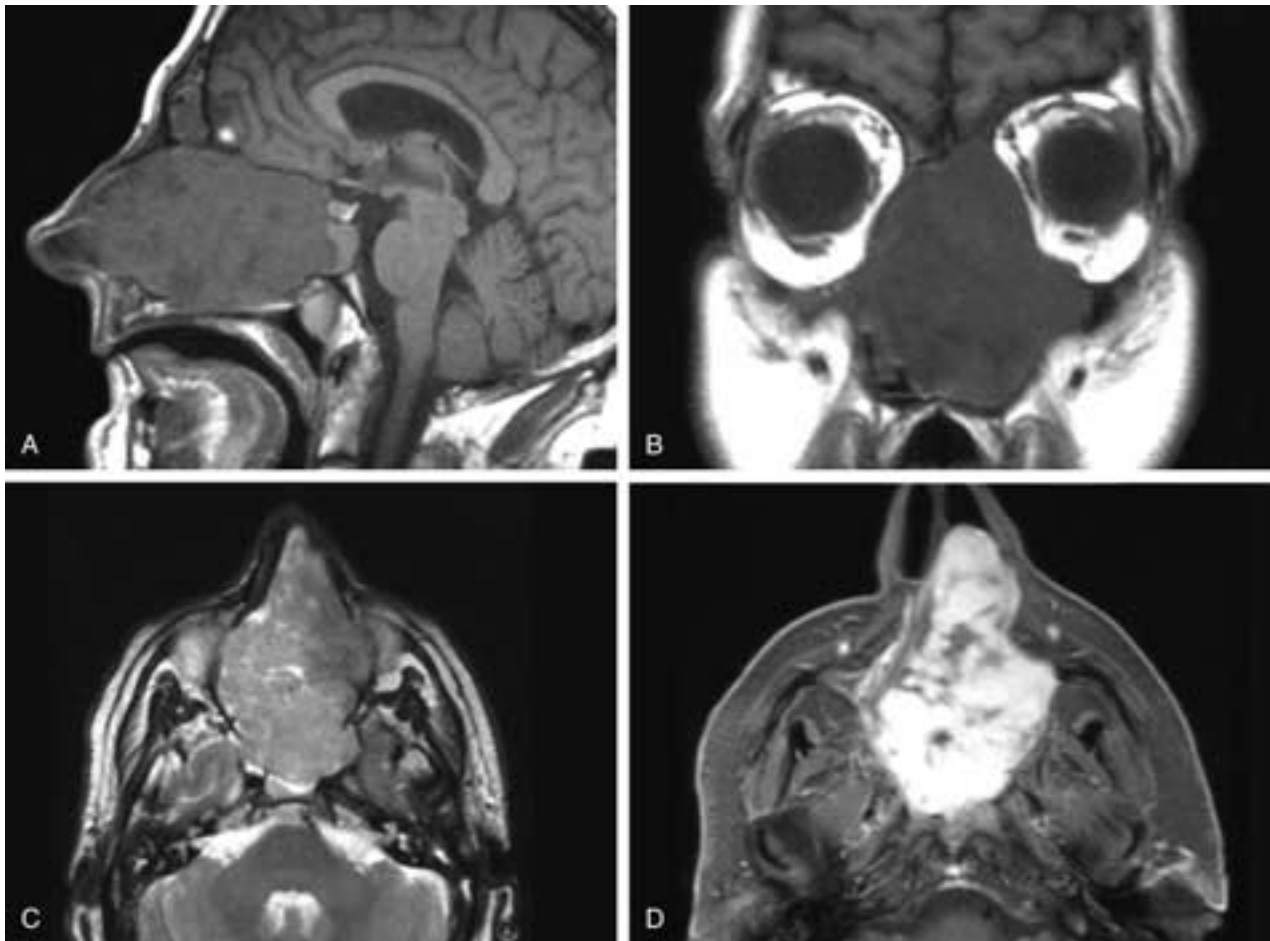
Sagittal (A) and coronal (B) T1-weighted MR images and axial T2-weighted (C) and T1-weighted, fat-suppressed, contrast-enhanced (D) MR images. In A and B, there is a fairly homogeneous, expansile nasal fossa mass that has elevated the floor of the anterior cranial fossa and bowed the lamina papyracea laterally. The medial floor of the left orbit is also elevated. There was no gross intracranial invasion or invasion of either orbit. The mass is nonhomogeneous on the T2-weighted and contrast-enhanced images. This patient had a leiomyosarcoma.
